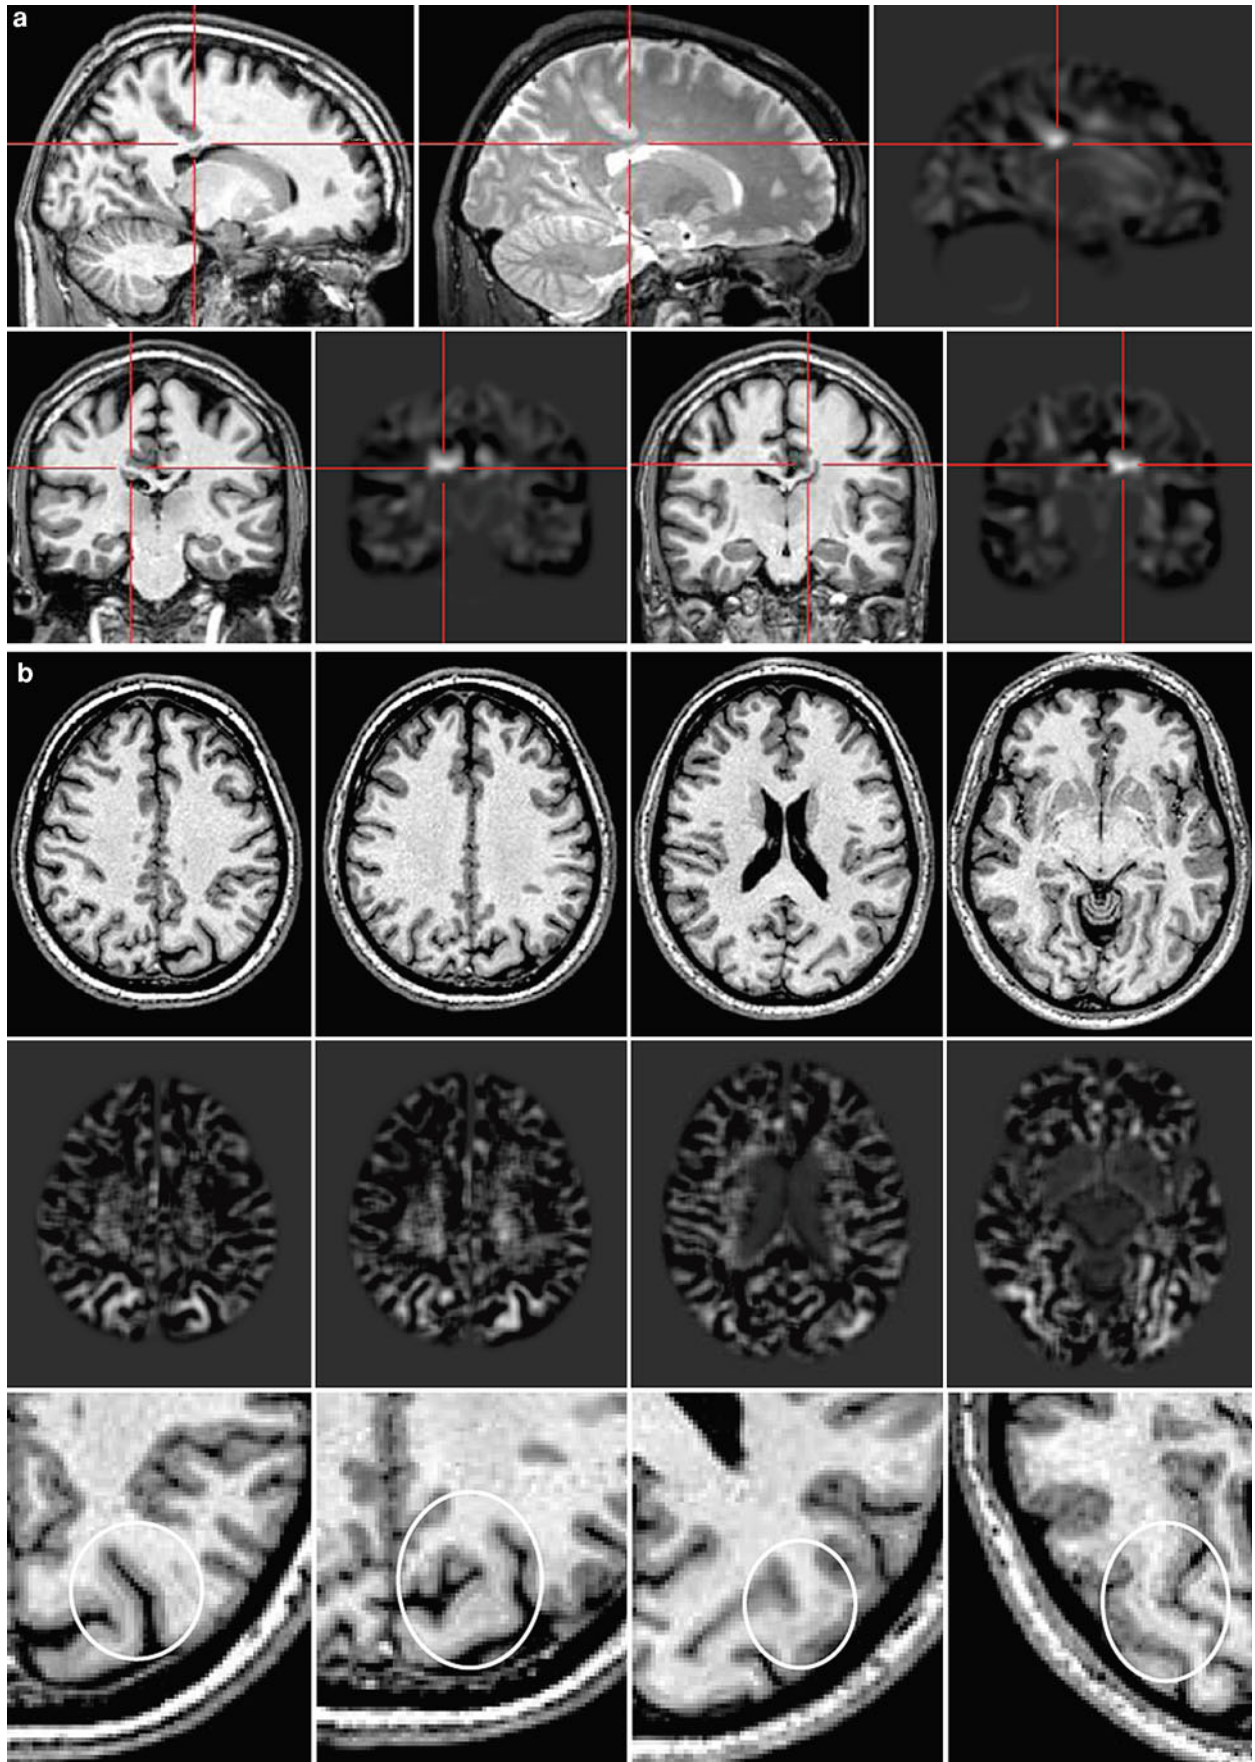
Further examples of morphometric analysis in FCD. a T1- and FLAIR-weighted images, extension image, and T1-weighted image after electrode implantation in a patient with epigastric auras and hypermotor seizures. The epilepsy was previously cryptogenic in spite of 1.5- and 3-T MRI. The extension image led to detection of the lesion by highlighting an abnormally deep sulcus in the left frontal lobe and guided the placement of a depth electrode in this suspicious
